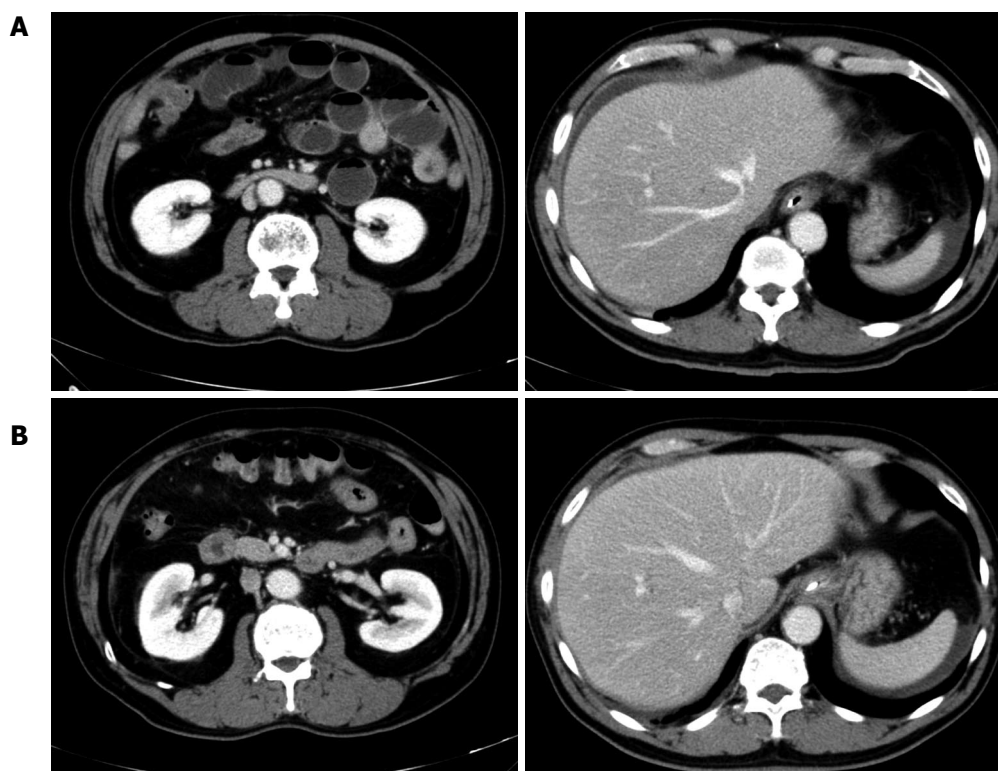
Abdominal computed tomography scan. A: Showing swelling of the partial segment of the small bowel and dilatation of the intestine (upper left) and ascites around liver and spleen (upper right); B: Demonstrating improvement in the partial swelling of the small bowel and the dilatation of the intestine and ascites collection.
